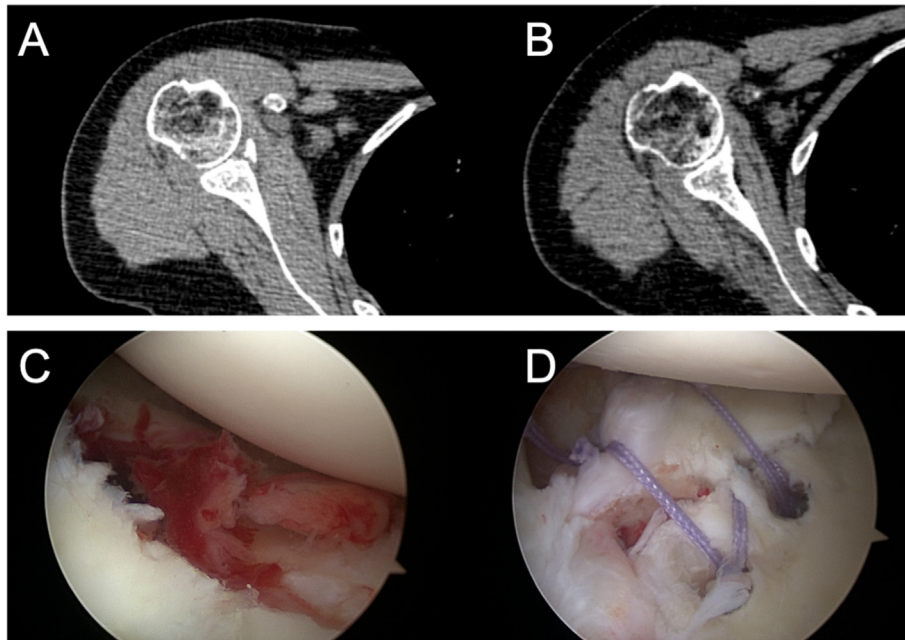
The transosseous sling-suture repair technique was used to treat the bony Bankart lesion in a 57 years old female. (A) The preoperative MRI scan showed the small sized bone fragment of the glenoid. (B) The MRI scan at 19 months postoperatively demonstrated the bone fragment healing. (C) The bone fragment at the anterior-inferior rim of the glenoid. (D) Two anchors were inserted to repair the bone fragment by the transosseous sling-suture repair technique.
